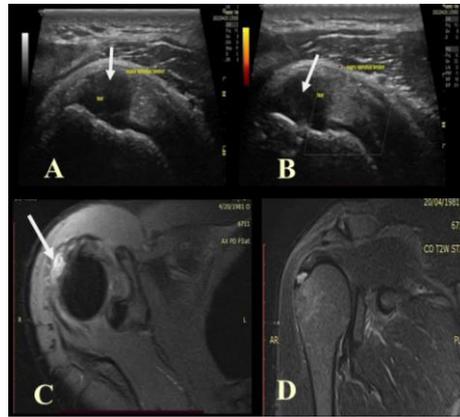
(A,B) Transverse section in right shoulder in crass position revealed evidence of full thickness tear of the supraspinatus tendon (white arrows) with 1 cm gap filled with fluid collection . (C, D) Coronal and axial MRI of the right shoulder revealed a 1cm fullthickness tear of the supraspinatus tendon (white arrows)
